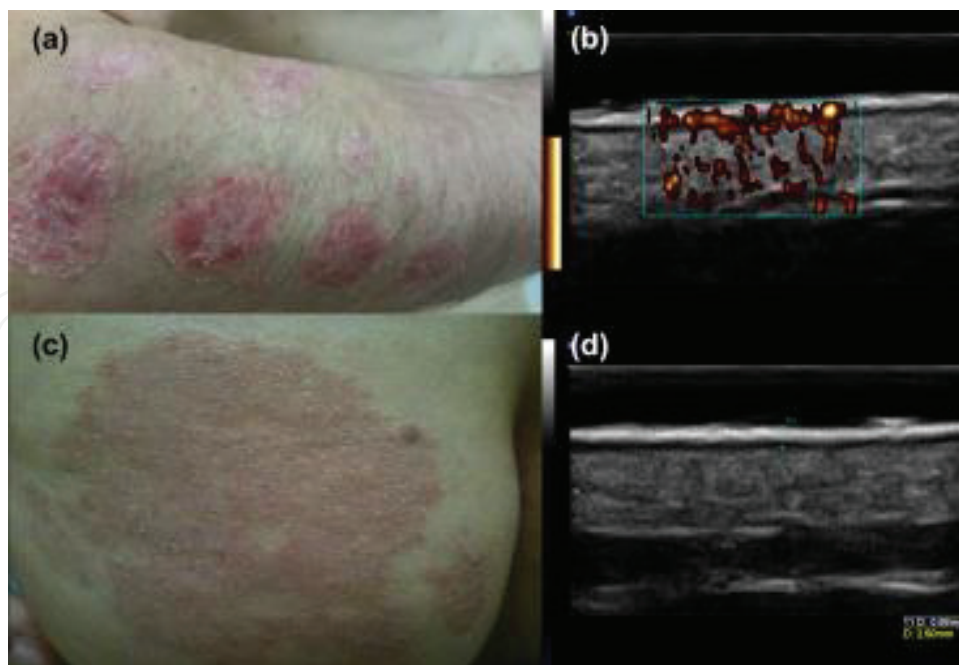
Clinical and sonographic images of active inflammatory and chronic stationary psoriasis plaques. (a) Active inflammatory, infiltrated red plaques covered by silvery scales; (b) thick hyperechoic epidermis, thin hypoechoic band in the upper dermis, thick echogenic and hypervascularised dermis; (c) pale red and less infiltrated stationary psoriasis plaque; (d) thickening of the epidermis and dermis with a thin hypoechoic subepidermal band and no blood vessels identified by Doppler.
